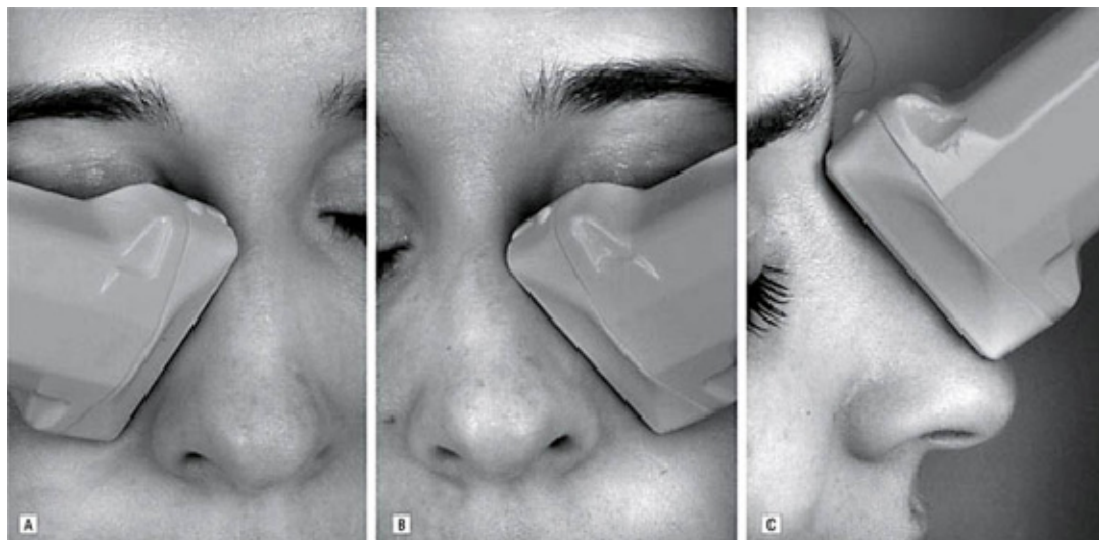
The positions of applying the ultrasound probe.¹¹ Courtesy from Oliver Thiede. A) Right lateral wall; B) Left lateral wall; And C) Nasal dorsum.
